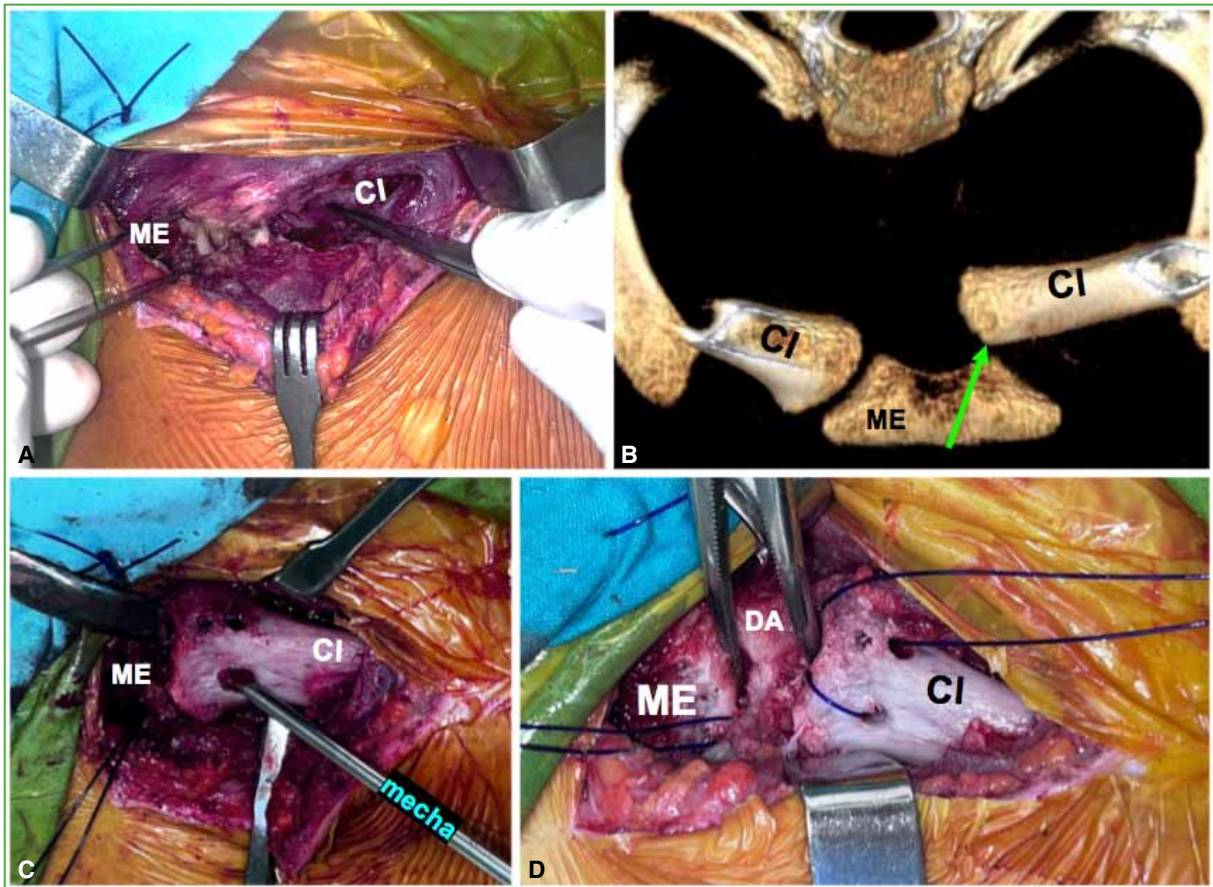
A. Surgical exposure after sternoclavicular approach, marking the posteriorly dislocated medial clavicular epiphysis (CI) with a closed clamp. Before joint reduction, tunnels are drilled in the sternal manubrium (ME), indicated by an open clamp. B. CT with 3-D reconstruction, craniocaudal view. The green arrow shows the direction of the manubrial tunnels with the clavicle dislocated posteriorly, which facilitates visualization and protects mediastinal structures from the drill bit. C. Clavicle reduced and tunnels drilled. Note the oblique trajectory of the drill. D. Thick PDS suture passed through the holes to shuttle the palmaris longus autograft and the high-strength suture tape. The articular disc (AD) is marked with a Crile forceps; it was preserved by creating posterior perforations for passage of the graft and suture.
